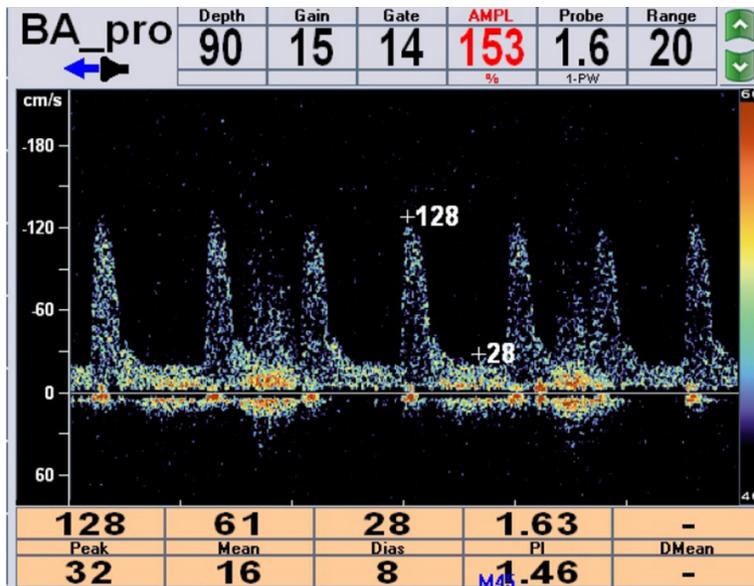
An intracranial ultrasound examination suggested abnormal blood flow in the basilar artery, which showed an uncommon high-resistance low-velocity waveform and images that differed from those of vascular stenosis, vascular spasm, or high cranial pressure.
